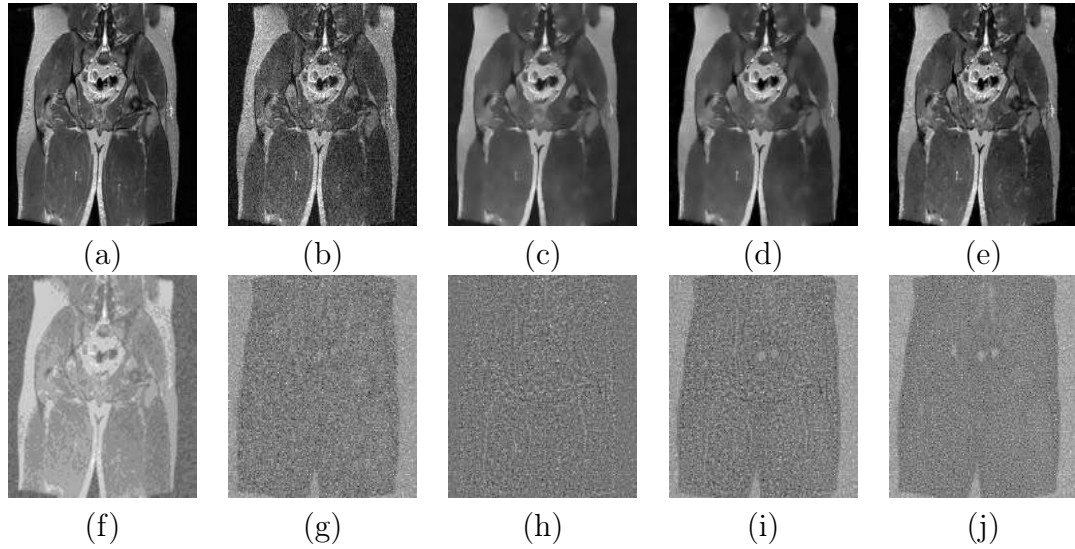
Real MR image 2: (a) Noise-free image, (b) noisy image (noise level = 9%), (c) NLM-output [46], (d) UNLM-output [42], (e) PCNNNI_IUNLM output, (f) Time Matrix, (g) actual noise, (h) residual of NLM, (i) residual of UNLM, (j) residual of PCNNNI_IUNLM.
